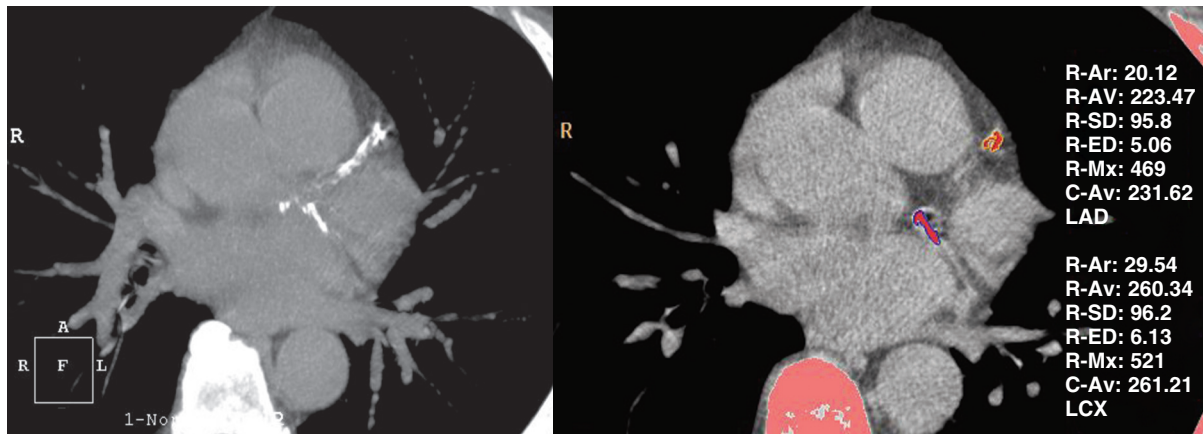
Example of coronary artery calcium scoring from a noncontrast CT (left panel) in which calcified foci are identified (right panel) within the left anterior descending (orange) and left circumflex (pink outlined in blue) coronary arteries. The region's area (R-Ar) and its average density in HU (R-Av) are displayed and used in the area-density calcium scoring calculation.
